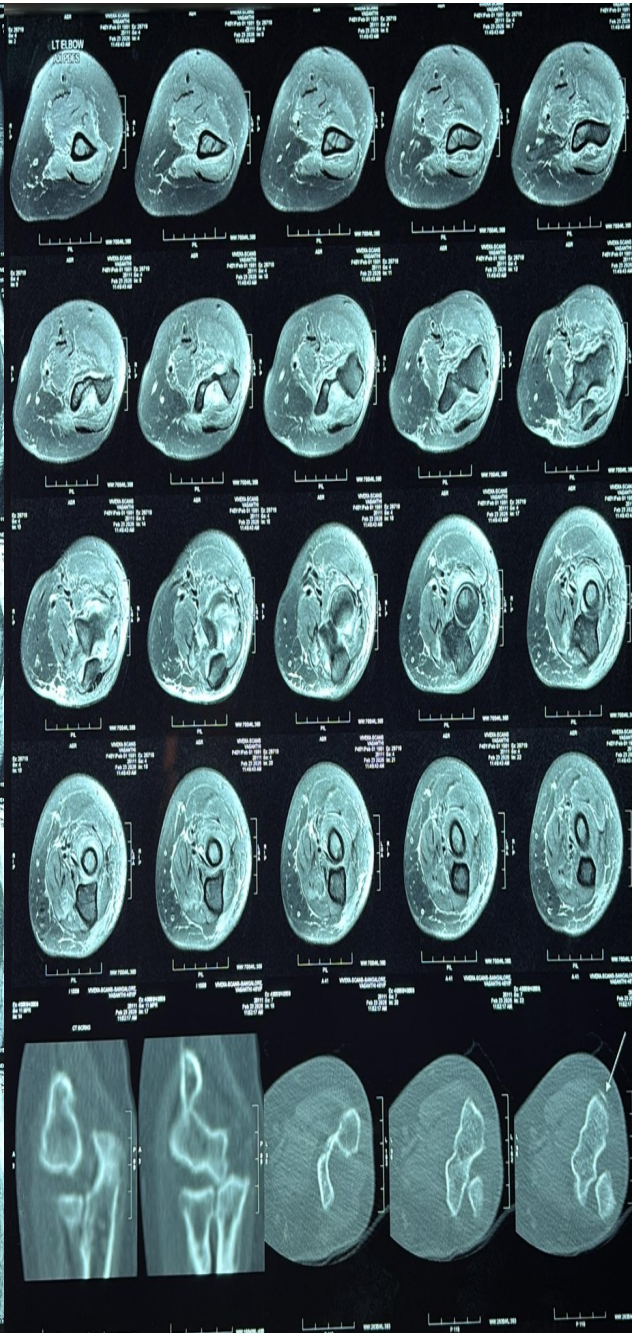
MRI left elbow — axial PDFS sequences and supplementary CT coronal/axial views confirming anterior radial head dislocation with disruption of the radiocapitellar line and no evidence of associated fracture.
